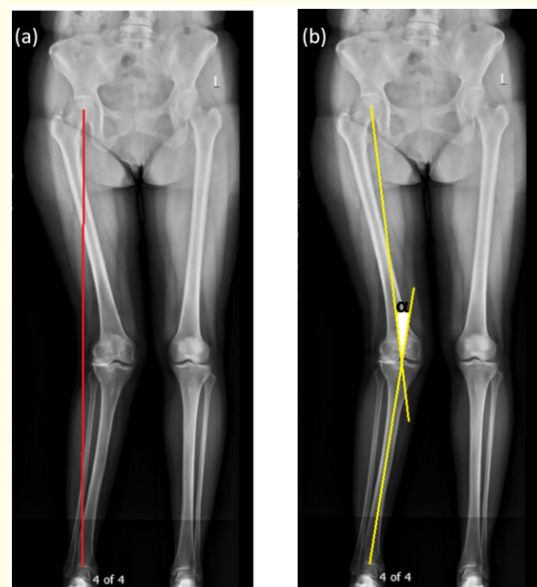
(a) Radiograph of long leg standing view to assess longitudinal axis alignment in the coronal plane as indicated by the red line (b) Determination of the angular correction by mechanical tibiofemoral angle α .
